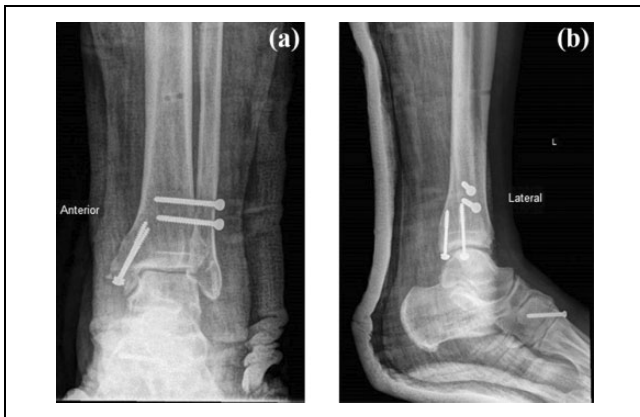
(a) Postoperative anteroposterior radiograph of the left ankle. (b) Postoperative lateral radiograph of the left ankle.
